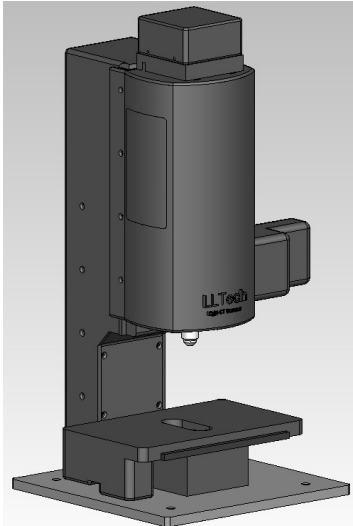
FFOCT prototype – Light-CT– developed by LLTech®.
